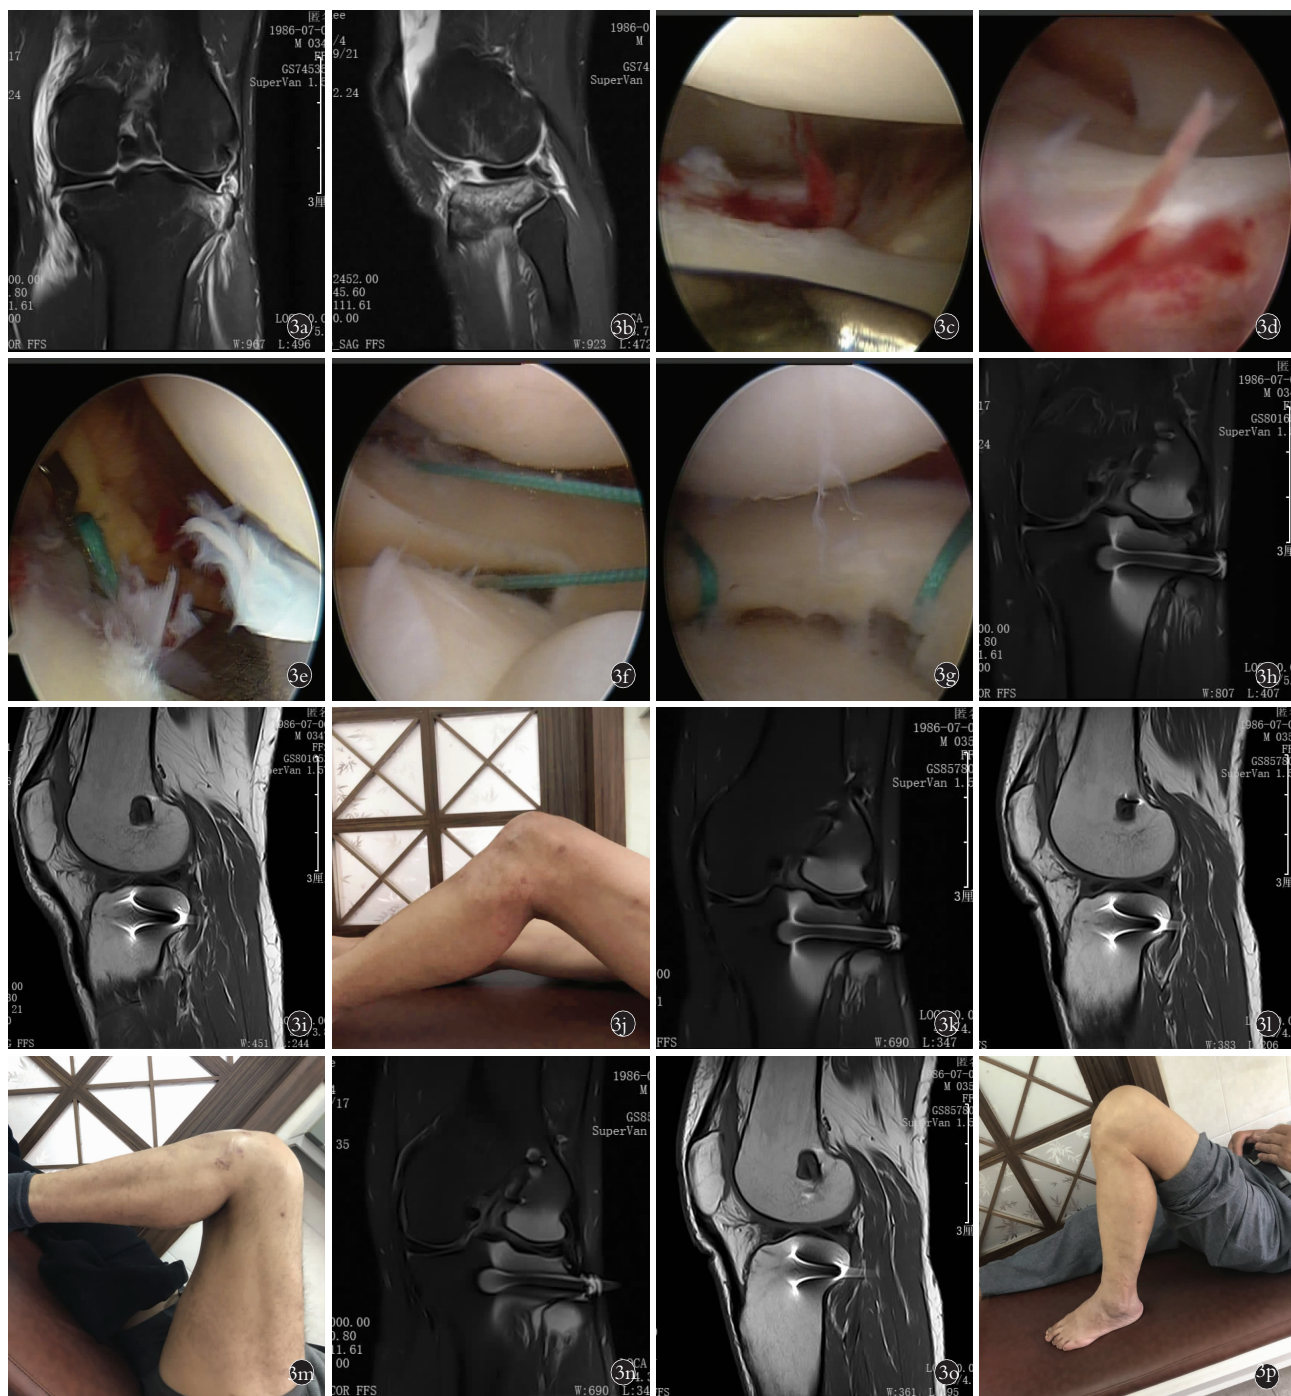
患者,男,39 岁,外侧半月板撕裂 3a,3b. 术前 MRI 冠状位、矢状位示外侧半月板红区桶柄样撕裂,撕裂半月板向内分离、移位 3c,3d. 术中关节镜下探查影像发现外侧半月板前角至体部红-红区桶柄样撕裂 3e,3f. 缝合,引线 3g. 半月板缝合后外观图 3h,3i. 术后 3 个月 MRI 冠状位、矢状位示外侧半月板复位良好 3j. 术后 3 个月外观图示膝关节功能良,屈曲 90° 3k,3l. 术后 6 个月 MRI 冠状位、矢状位示外侧半月板复位良好,半月板愈合 3m. 术后 6 个月外观图示膝关节功能良好,屈曲 125° 3n,3o. 术后 12 个月 MRI 冠状位、矢状位示外侧半月板复位良好,半月板愈合良好 3p. 术后 12 个月外观图示膝关节功能优,屈曲 135°
